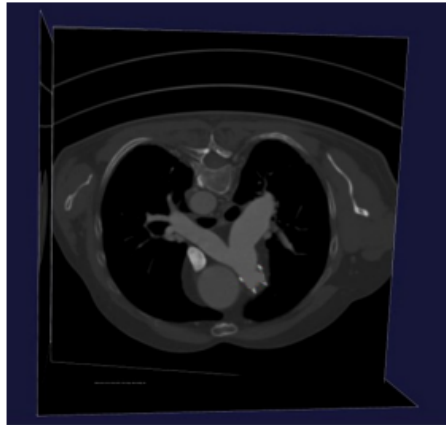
An example of a CT representing the pulmonary artery visualised using VMTK [21].
